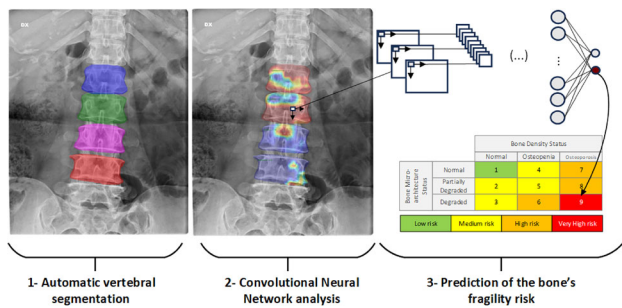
Multi-stage deep-learning application for the opportunistic screening of bone's fragility risk from X-ray
